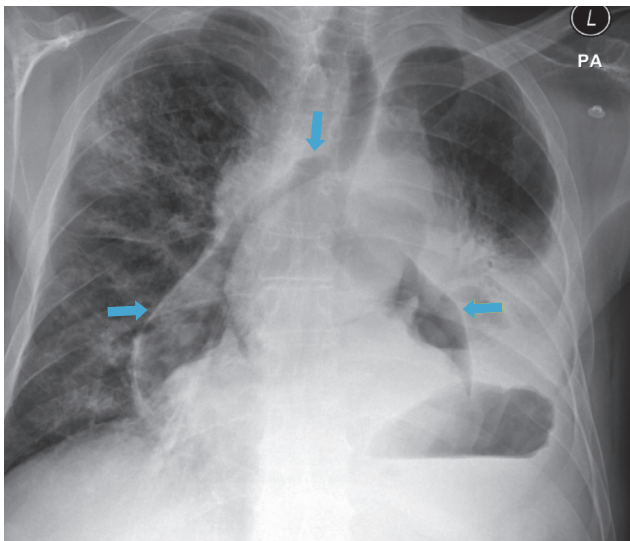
Chest PA view radiograph showing air (blue arrows) around the heart, the aorta and the main pulmonary artery
